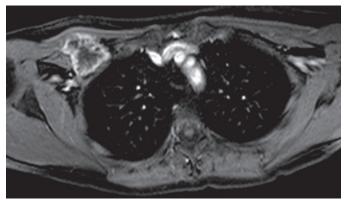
Axial post-contrast T1 fat suppressed MRI, demonstrating peripheral enhancement of a centrally necrotic mass in the right axilla in proximity to subclavian vessels.
